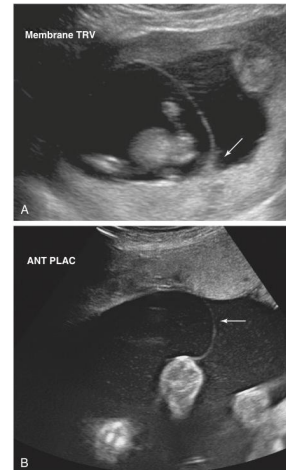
A, Real-time ultrasound with a thick vertical amnio-chorionic septum (membrane) separating one twin (left side) from the second twin on the right. The arrow (right) points to a "peak" or "inverted V" suggesting dizygotic twins. B, Ultrasound of a thin vertical membrane separating one twin on the left side from the second twin on the right suggesting a monochorionic gestational sac. ANT PLAC, Anterior placenta; TRV, transverse view of membrane.
